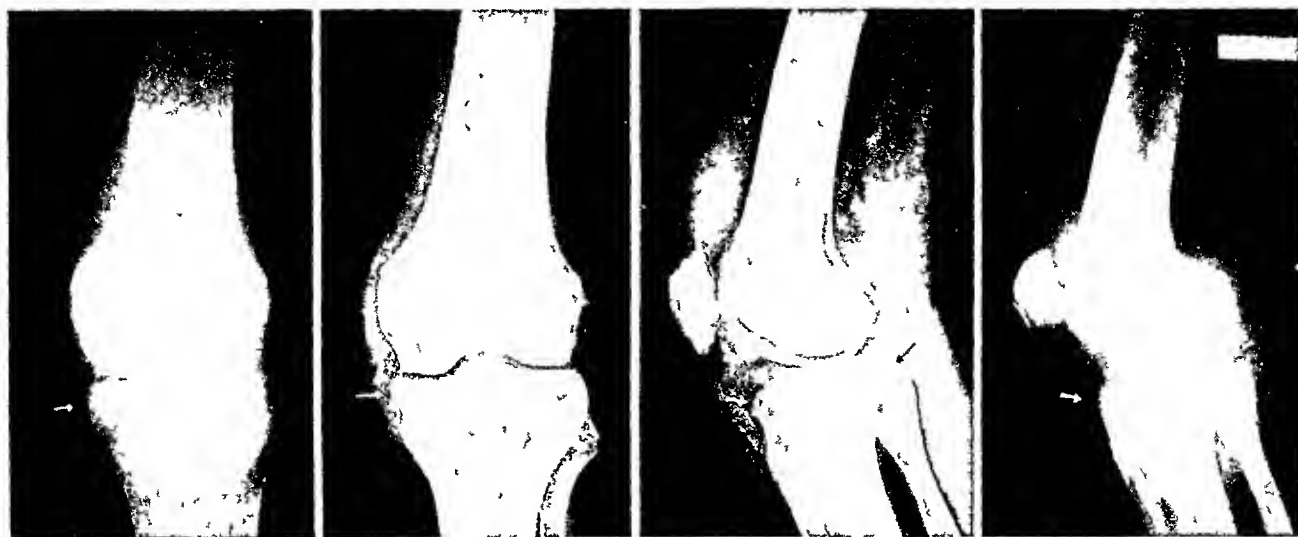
Proved case, recognizable roentgenographically as early tuberculosis. Roentgen findings: Severe synovitis, joint space well preserved, small areas of bone roughening and deposit anteriorly, posteriorly, and medially at the margins of the upper tibial articular surface. History: R. D., male, aged twenty-one, had spent eight months in a sanatorium because of pulmonary tuberculosis. Four months ago struck his left knee, since when he has had pain and swelling. Roentgen report: strongly suggestive of tuberculosis. Pathologist's report: tuberculous synovitis.
